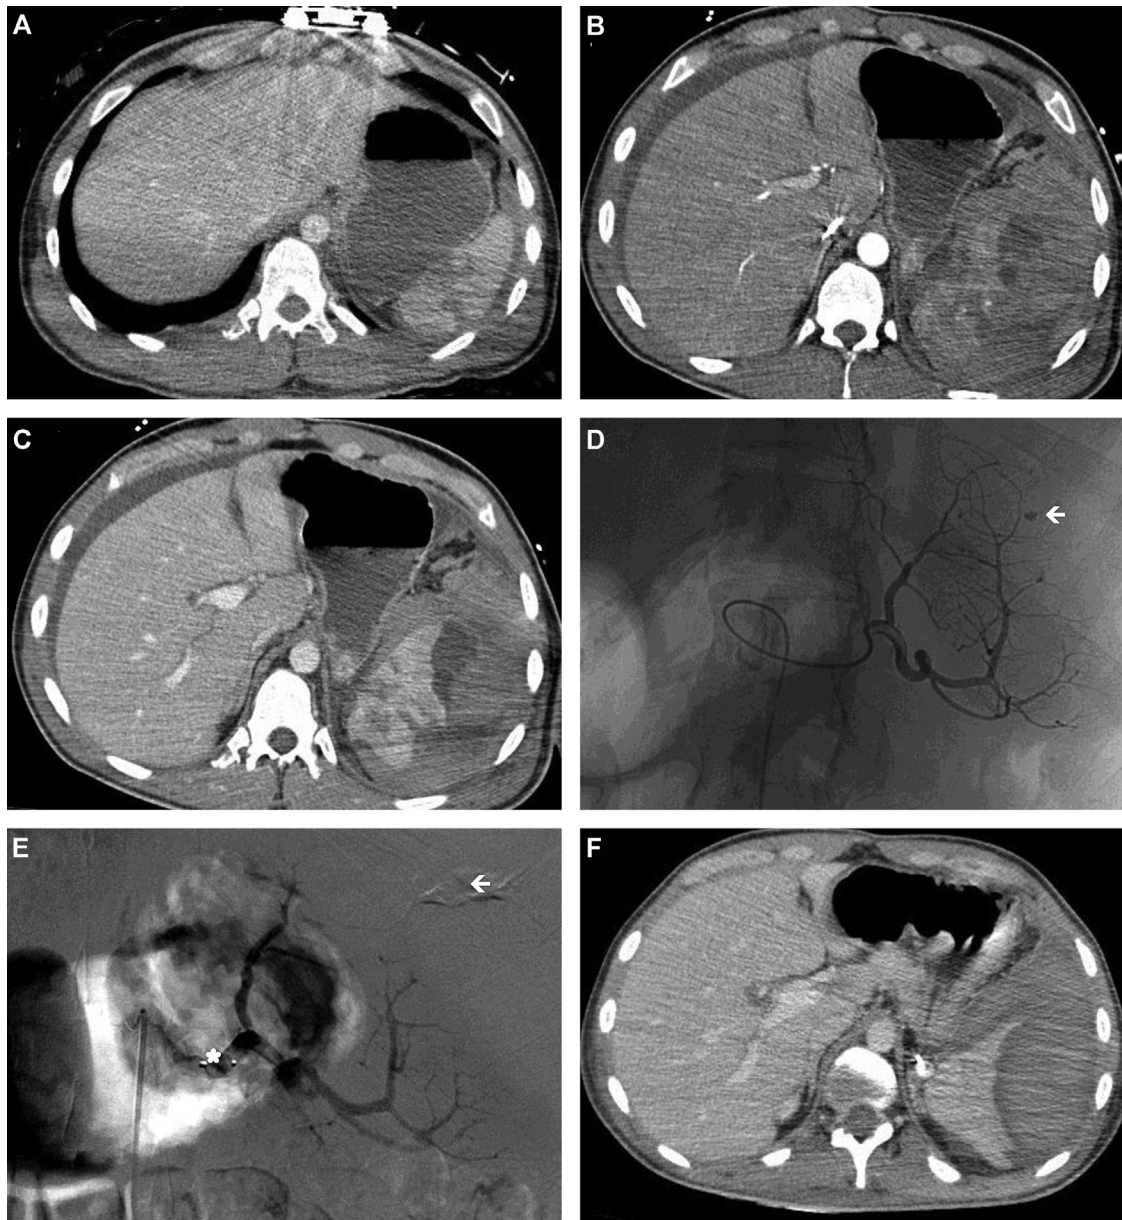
A 24-year-old male patient with no prior history fell from 20-m height while riding an all-terrain vehicle; vital signs were stable when patient presented to the emergency room. Multiple trauma noted on contrast-enhanced CT scan; multiple rib fractures, pneumothorax, grade 3 splenic trauma with several parenchymal lacerations, moderate-sized hemoperitoneum, but without ongoing bleeding or contrast extravasation [3A], fracture of the right acetabulum and femoral diaphysis. Patient monitored in the ICU and then managed by the orthopedic surgery service. The patient's vital signs, clinical exam and hemoglobin were initially stable. A CT scan on day 5 showed no progression of the splenic lesions. On the 9th day, the patient had acute onset of severe abdominal pain with an increase in abdominal girth and a fall in hemoglobin/hematocrit. Urgent CT scan showed: several leaks of contrast in the arterial phase from the region of the splenic hematoma [3B] with a marked increase in the hemoperitoneum in the portal phase [3C]. The patient was transferred to the ICU for management of hemorrhagic shock and urgent angiography with splenic artery embolization. Arteriography revealed several very localized contrast extravasations, one of which was sizeable and associated with a more rounded image (arrow) [3D]. Hyperselective embolization of this arterial branch with a fragment of Curaspon® gelatin sponge (arrow), followed by proximal arterial embolization with a plug were carried out successfully (asterisk) [3E]. The patient's clinical and laboratory course were good. Follow-up CT scan on the 24th day post-embolization [3F] showed a well-vascularized parenchyma with regression of the splenic hematoma.
